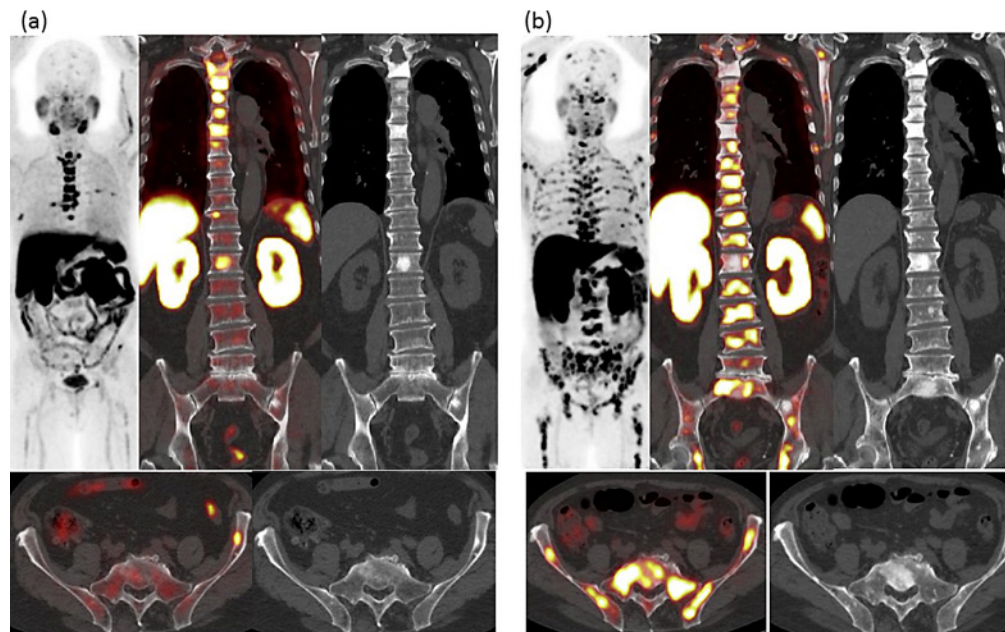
A 69-year-old man with castration-resistant prostate cancer was treated with radium-223 therapy. a The first ^{11}C -choline PET/CT showed multiple osteoblastic lesions and abnormal ^{11}C -choline uptake in the spine and pelvis, suggesting viable tumors. b The second ^{11}C -choline PET/CT at the end of the radium-223 therapy showed a decrease in existing ^{11}C -choline uptake, but multiple new appearances of osteoblastic and nonosteoblastic lesions with abnormal ^{11}C -choline uptake in the spine, pelvis, ribs, and femur, suggesting multiple viable bone metastases. We can assume progressive metabolic disease according to the two ^{11}C -choline PET/CT scans.
